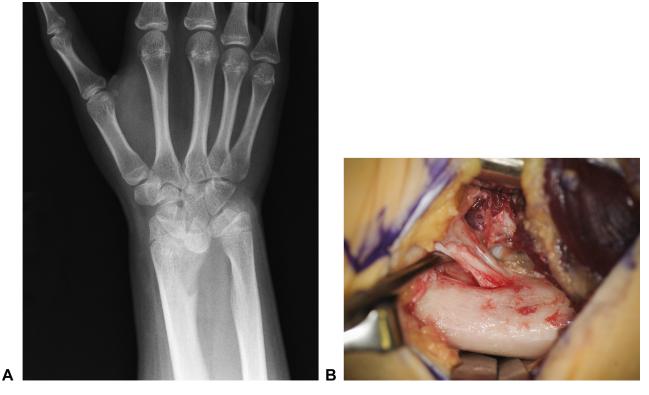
A 17-year-old girl with Madelung deformity and prominent ulna. (Courtesy of Shriners Hospital for Children, Philadelphia, PA.) A X-ray with increased radial inclination and ulnar positive variance. Note radiolucency in the metaphysis of the radius, consistent with the presence of a Vickers ligament. B Operative findings with a markedly thickened Vickers ligament.
